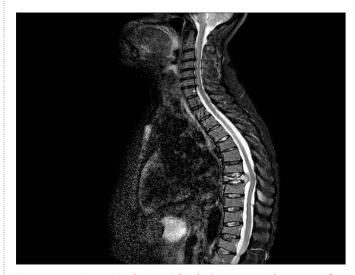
MRI Spine: Sagittal T2 weighted fat-suppressed sequence [no legend as this has been embedded into text as the answer to a question]
